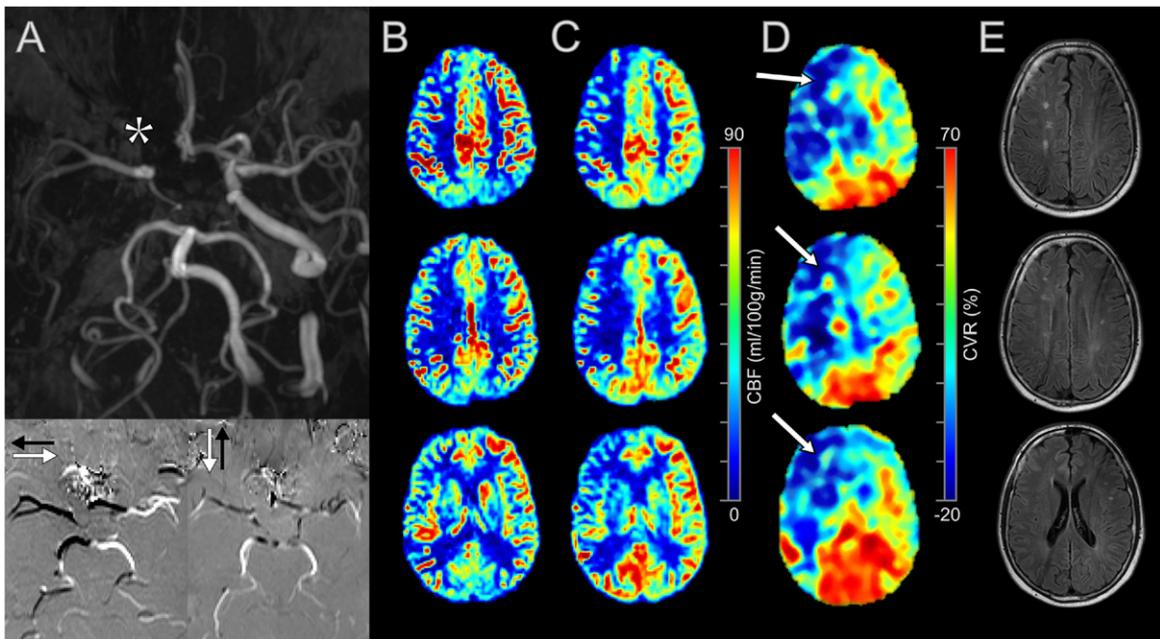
Example of 50-year-old patient with a right-sided ICA occlusion. MR time-of-flight image and flow direction angiography (A) shows the occluded right internal carotid artery in combination with a missing pre-communicating segment (A, star) of the right anterior cerebral artery and patent pCom arterial spin labelling (ASL) MRI perfusion images before (B) and after (C) the acetazolamide vasodilatory challenge show three consecutive slices from caudal (bottom) to cranial (top) and an increase in CBF is observed in the left hemisphere. The right hemisphere shows no increase and even a slight decrease in CBF. The percentage reactivity map (D) shows the absence of reactivity in the right hemisphere, where darker blue areas (D, arrows) show a negative reactivity, corresponding with hemodynamic steal. FLAIR MRI images (E) show internal borderzone infarcts in the semiovale centre.
